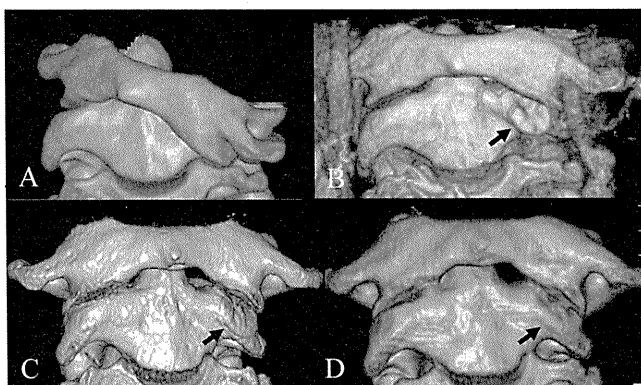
Three-dimensional-CT images before (A) and after the closed manipulation (B, immediately; C, 2 months; D, 6 months after closed reduction) in case 5 with a severe C2 facet deformity. The incomplete remodeling of C2 facet deformity is seen (arrow in B–D).
